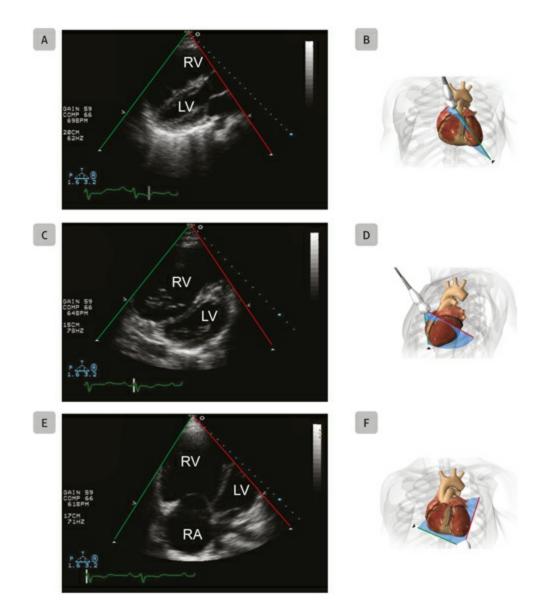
Right ventricular dysfunction. A 67-year-old male presented to the emergency room with hemodynamic instability and underwent a transthoracic echocardi-ography examination. (A,B) The parasternal long-axis view revealed acute dilatation of the right atrium (RA) and the right ventricle (RV). (C,D) The left ventricle (LV) was compressed by the RV as shown in the parasternal midpapillary short-axis view. (D,E) The apical four-chamber view confirmed RV and RA dilatation.
